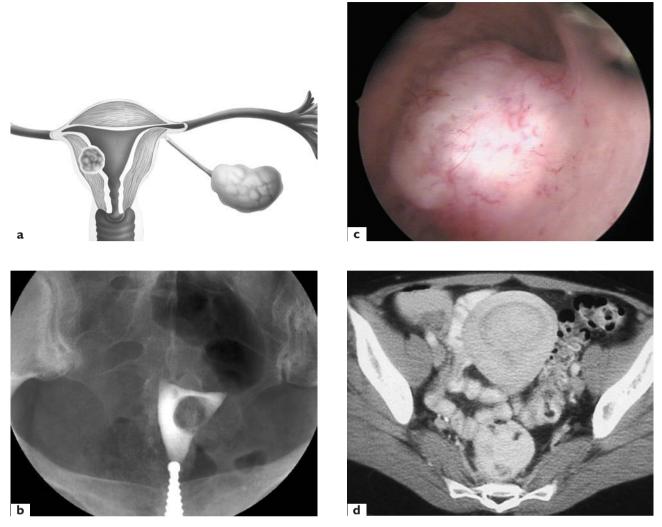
(a)–(d) Submucosal fibroids the greatest diameter of which was inside the uterine cavity: (b) hysterography; (c) hysteroscopy; (d) computed tomography
